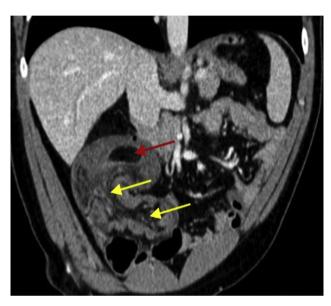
Abdominal CT coronal reconstruction that shows the head of the invagination, corresponding to a lipoma (red arrow) and the large ileocolic invagination with vessels and mesenteric fat inside the lumen of the colon (yellow arrows).
